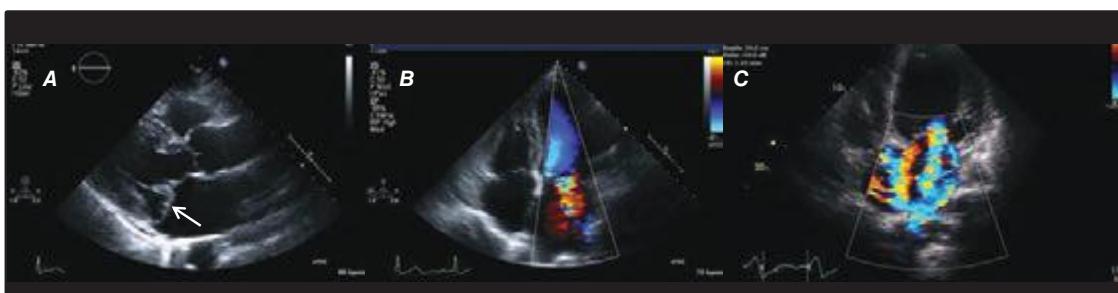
23 A. Mitral valve prolapse with posterior leaflet visualized prolapsing behind the plane of the anterior leaflet (arrow). B. Color flow Doppler showing mitral regurgitation in a patient with mitral valve prolapse. C. Severe functional mitral regurgitation in a patient with a dilated left ventricle.
